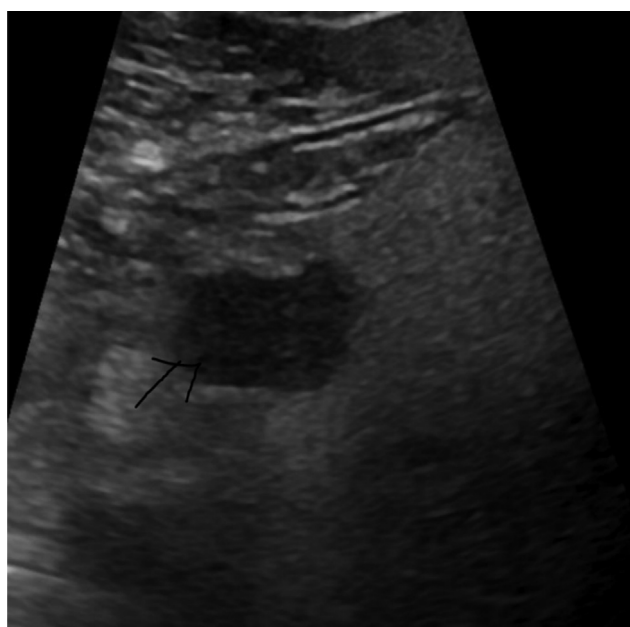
Ultrasonography shows a well-demarcated partly exophytic hypoechoic lesion in the left lobe of the liver.
